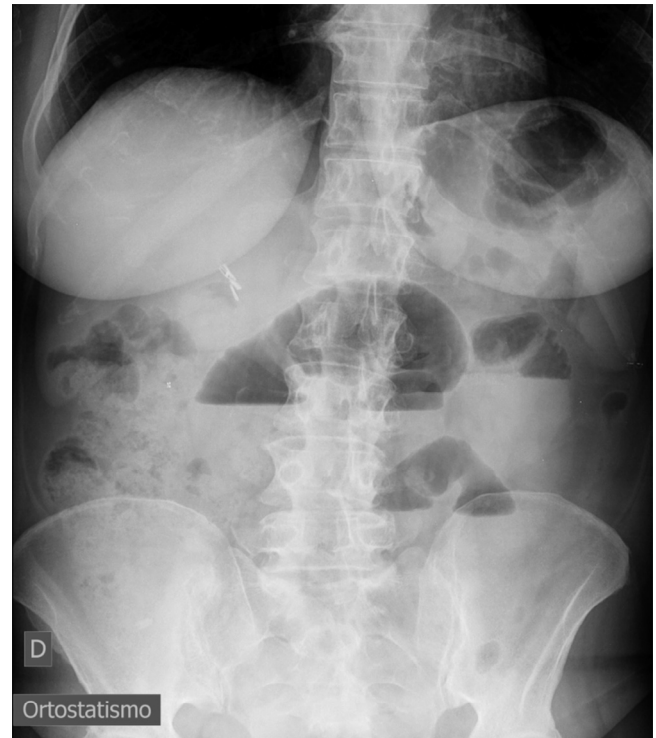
Abdominal erect anteroposterior radiograph shows dilated small bowel loops with air-fluid levels, suggesting obstruction, with normal gas pattern distribution of the colon. Surgical clips are present in the right upper quadrant, in keeping with previous cholecystectomy.
